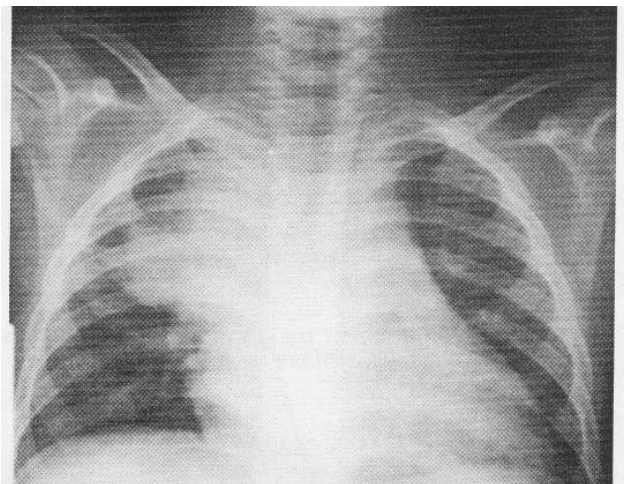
Chest radiograph with wide superior mediastinum and apical opacity right lung.
